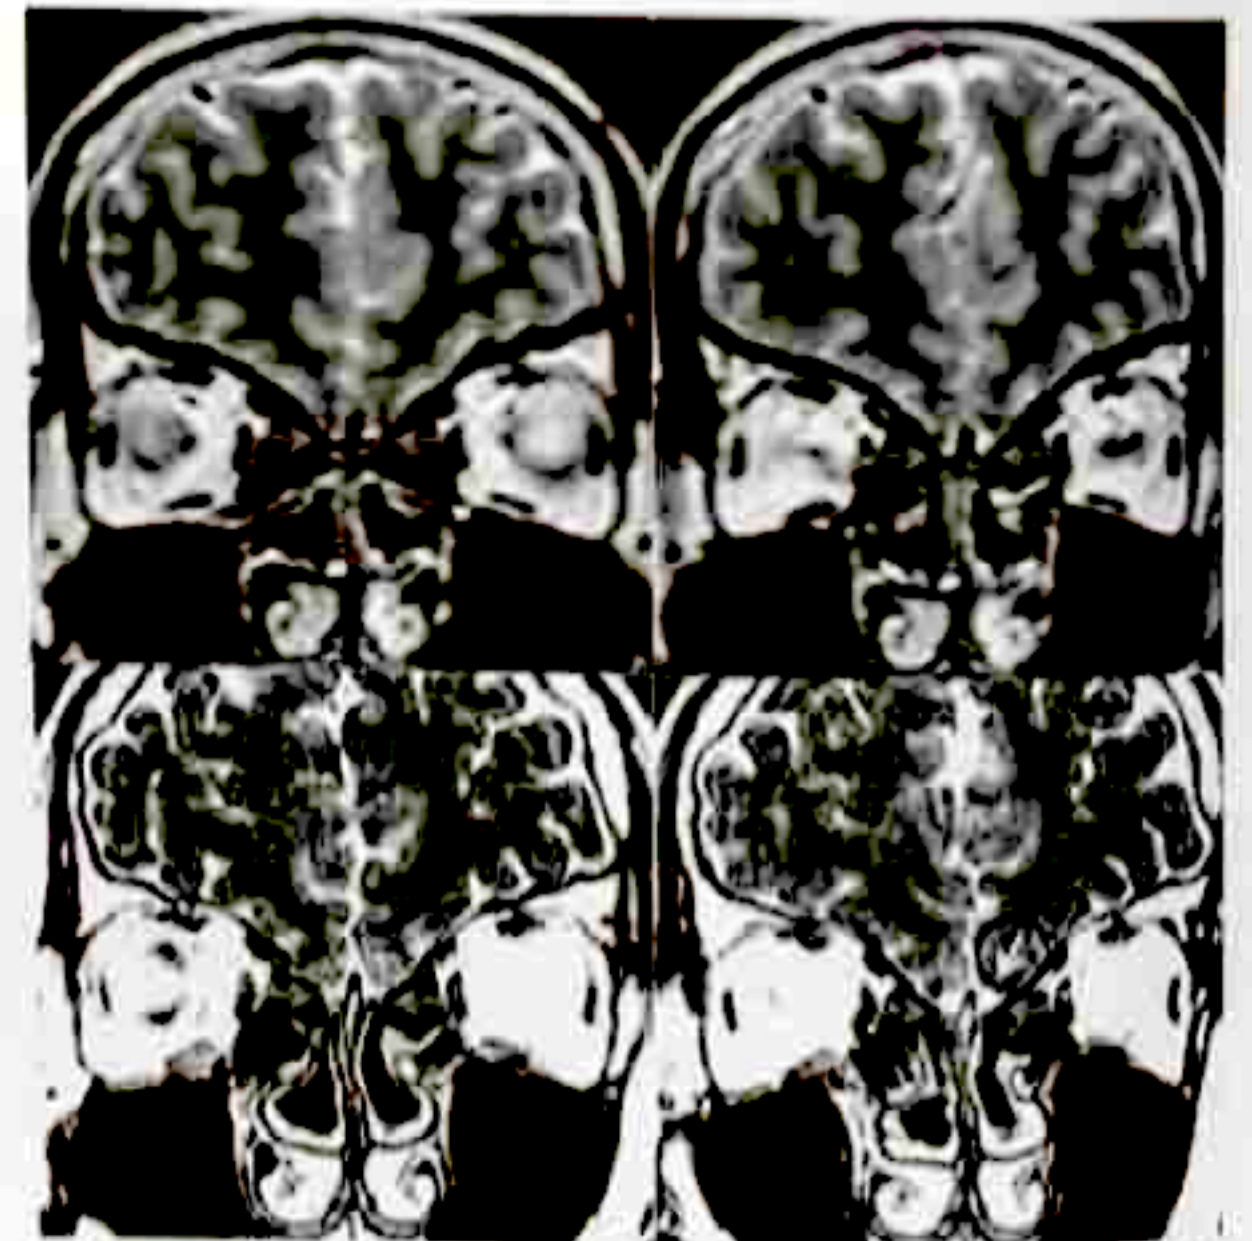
Coronal T2-weighted images of our patient demonstrating absent olfactory bulbs (arrow) and shallow olfactory sulci (encircled arrow).
